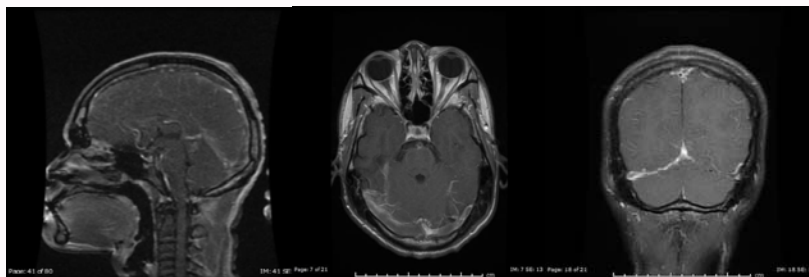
Sagittal, axial and coronal MRI with MRV images showing filling defects involving the superior sagittal sinus, right jugular bulb, sigmoid and the transverse sinus.
